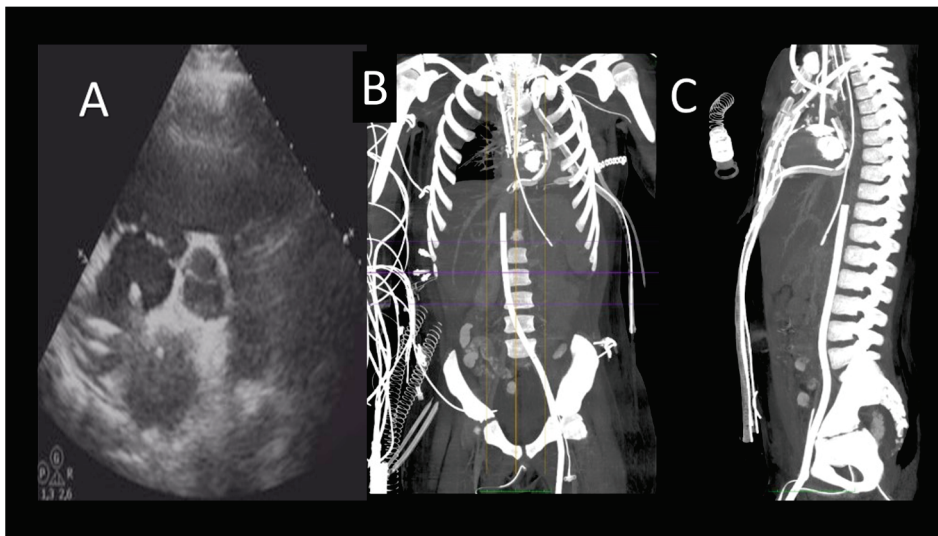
Evaluation after veno-arterial extracorporeal membrane oxygenation (VA ECMO) implantation. (A) Transthoracic echocardiography showing the correct position of the right atrial (RA) cannula. (B) Cardiac computed tomography (CCT) scan showing correct position of RA and femoral vein ECMO cannulas (C) Sagittal CCT showing correct position of RA and femoral vein ECMO cannulas.
